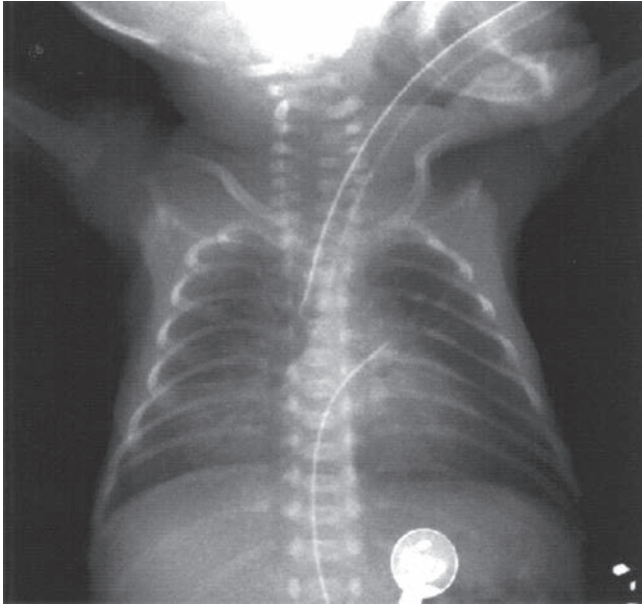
Chest x-ray demonstrating “ground glass” infiltrates consistent with respiratory distress syndrome (with a more focal area of infiltrate or atelectasis in the medial right lung base).
